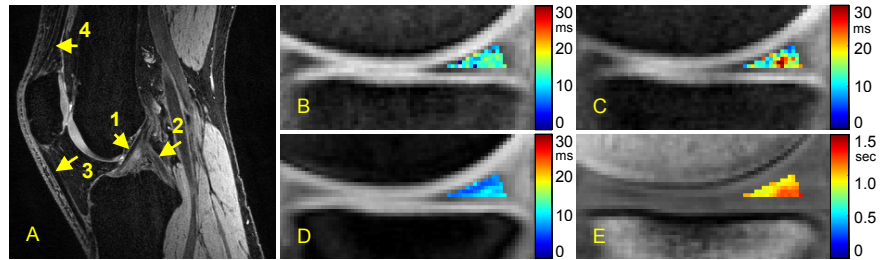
T2-weighted fat-suppressed sagittal MR image of the knee of a 28-year old subject (A) and corresponding calculated T_2 (B), $T_{1\rho}$ (C), T_2^* (D) and T_1 (E) maps with a segmented medial meniscus. The arrows in (A) show the musculoskeletal tissues of interest: AC (1) and PC (2) ligaments, quadriceps (1) and patellar (2) tendons.
